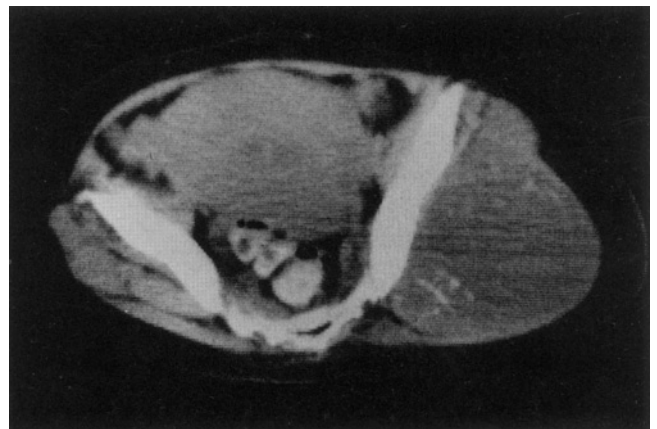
CT scan showing a large chondrosarcoma arising from the iliac wing approaching the sacroiliac joint involving the gluteus maximus muscles. This patient is not a candidate for a posterior flap hemipelvectomy and required an anterior flap hemipelvectomy for adequate margins to be obtained posteriorly.
